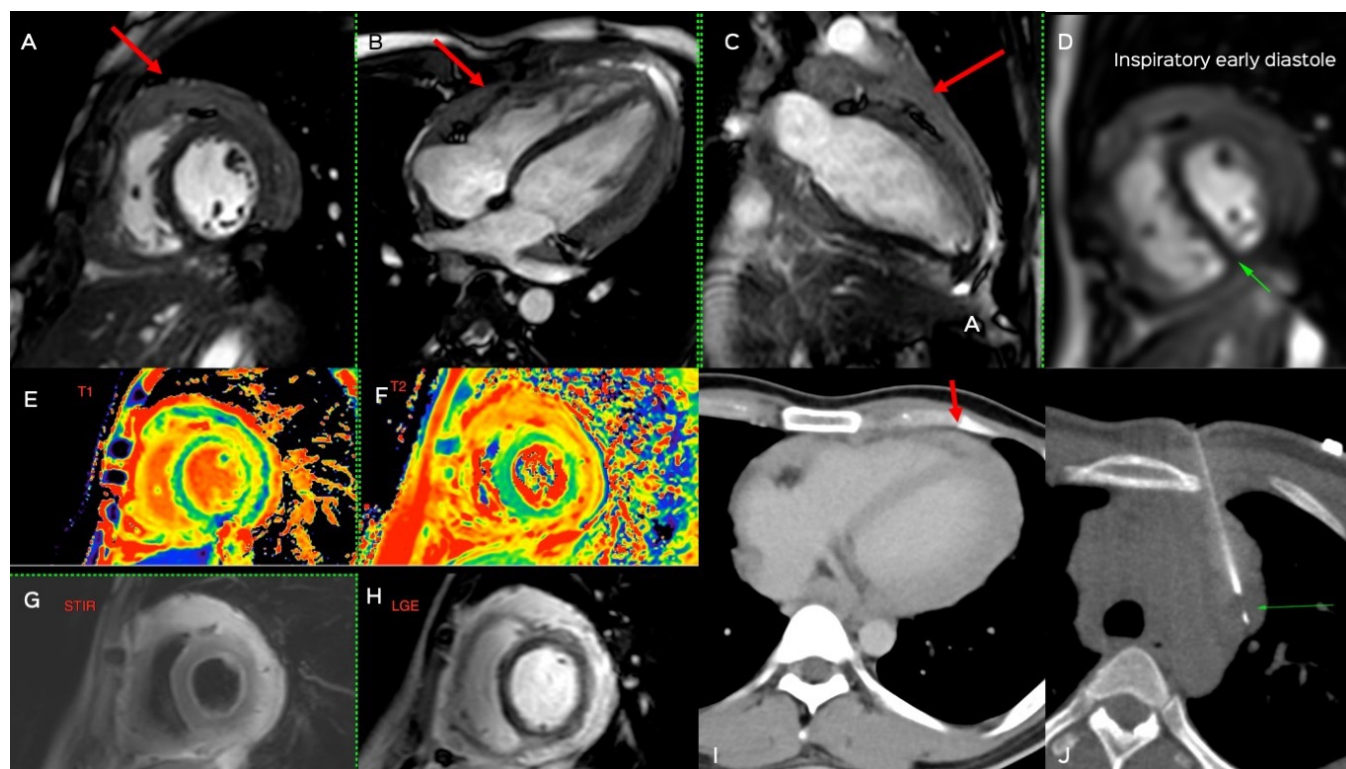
(A-J): 33-years old with fever and weight loss. The cine cardiac images (A – short axis, B – four chamber and C – two chamber) showed normal systolic function and mild biatrial dilatation. Marked thickening of the pericardium is noted (arrows in A, B & C). Real-time imaging (D) shows leftward septal deviation in inspiration during early diastole, a sign of RV-LV disassociation that is the hallmark of constrictive pericarditis. The T1 (E), T2 (F), STIR (G) and late gadolinium enhanced (H) images show the marked thickening of the pericardium with epicardial edema. The axial contrast CT scan (I) shows pericardial thickening without calcification. A CT guided left para-aortic node biopsy (J) confirmed the diagnosis of tuberculosis.
